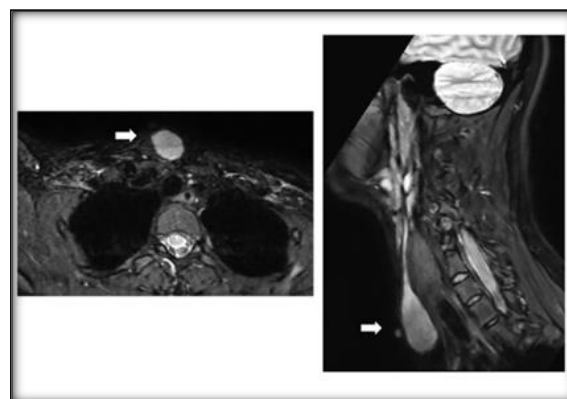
Axial turbo spin-echo T2-weighted Dixon MRI scan shows the external opening at the lower cervical region (arrow). Sagittal turbo spin-echo T2-weighted Dixon MRI scan shows the exit location of the fistula in the neck (arrow)
